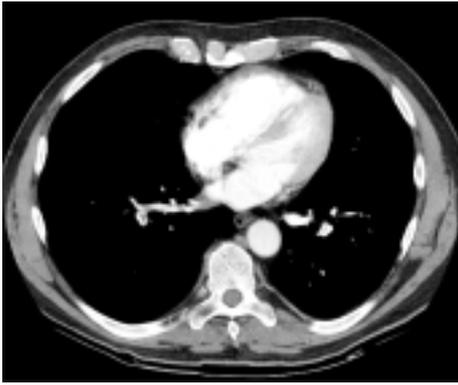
Right ventricular dilation at multislice computed tomography.
